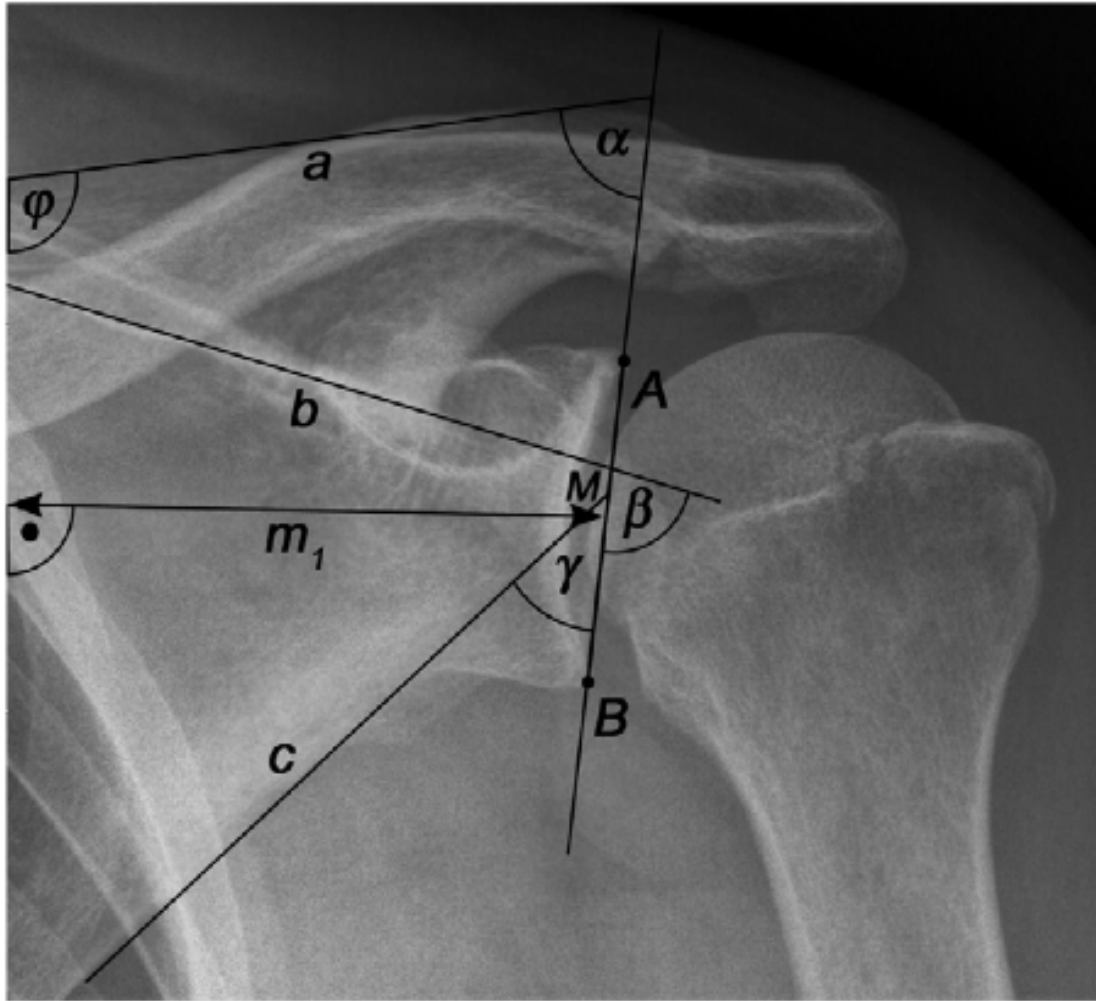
Definition of glenoid inclination angles on plain radiograph of shoulder.
